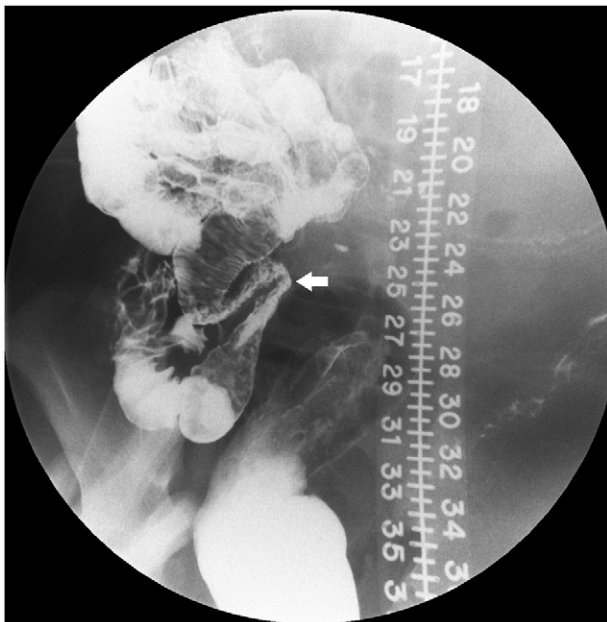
Small bowel follow-through in an 11-year-old boy confirmed to have Crohn's disease—"spot" radiograph demonstrates a stricture in the terminal ileum (arrow).
